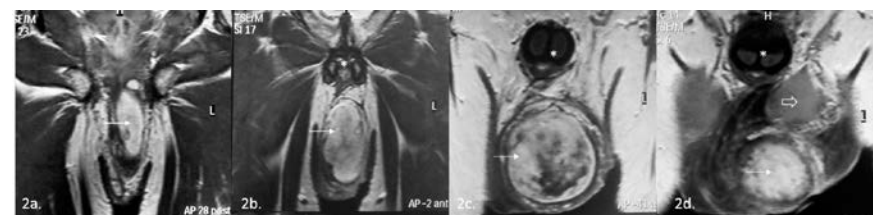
Magnetic resonance imaging of the scrotum. The T1-TSE images, in coronal plain, show a solid, lobulated mass (arrow) in the left hemiscrotum extending from the base of the corpus cavernosum (*) posteriorly, to the posterior-inferior edge of the left testicle (open arrow). The mass demonstrates a heterogeneously high T1 signal intensity, surrounded by a thin low signal intensity capsule and is clearly separated from the ipsilateral testicle (open arrow). The high T1 signal intensity is characteristic of fat-containing tumors (both benign and malignant).
